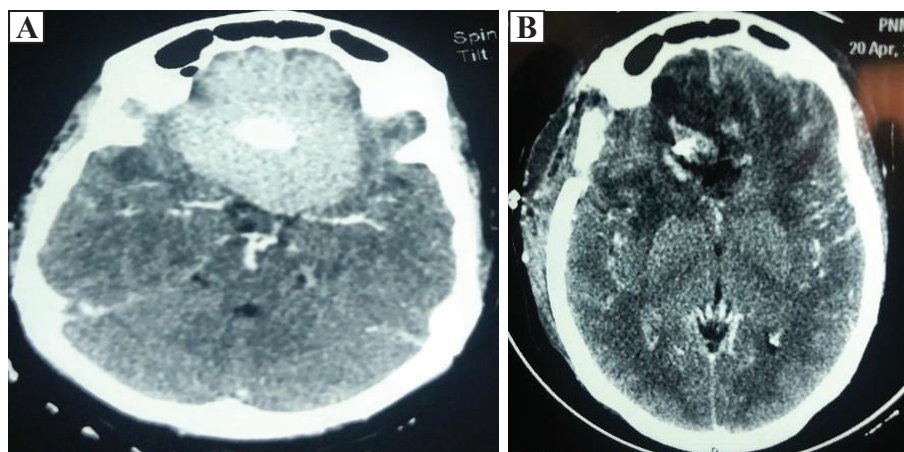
Olfactory groove meningioma (A: preoperative CT scan; B: postoperative CT scan)
